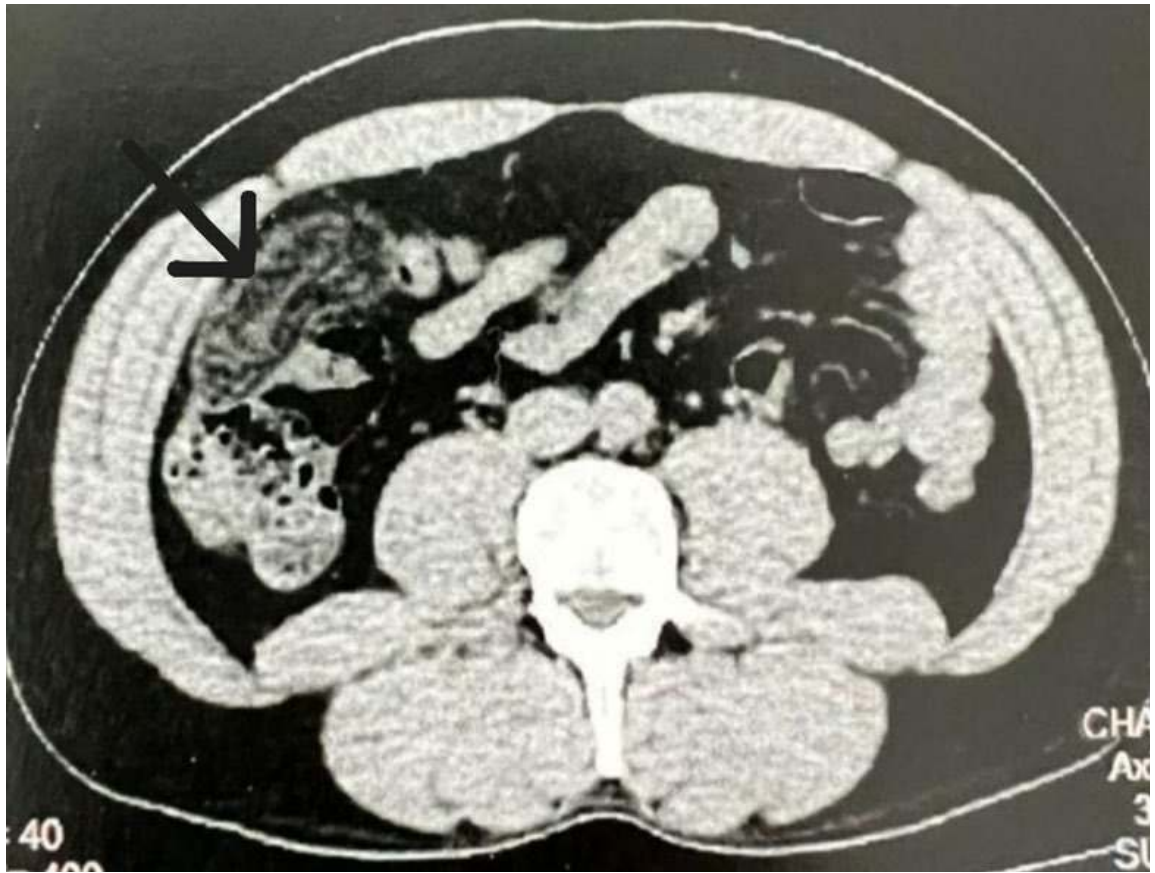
Contrast-enhanced axial computed tomography image of the upper abdomen reveals an ovoid heterogeneous fatty mass with internal striations, positioned within the greater omentum anterior to the ascending colon and subjacent to the anterior abdominal wall (black arrow), radiological features pathognomonic of omental infarction.
